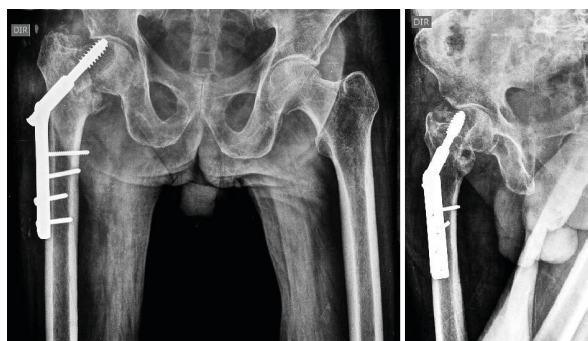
AP radiographs of the pelvis and side view of the right hip 120 days post-operatively, showing varus collapse of the fracture, as well as cut-out of the cephalic screw.
